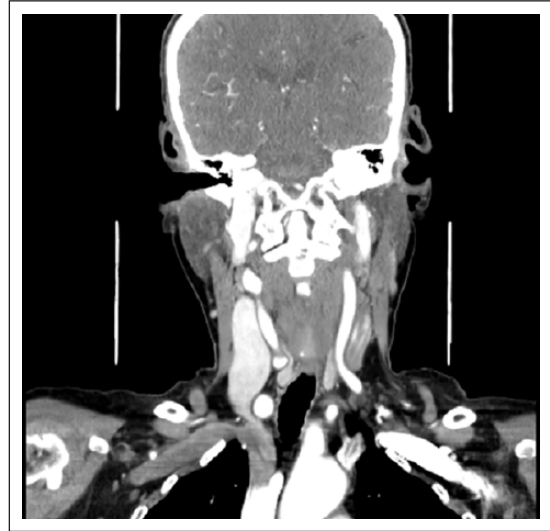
Contrast-enhanced coronal CT image is showing the extent of the dilatation of the right internal jugular vein.
